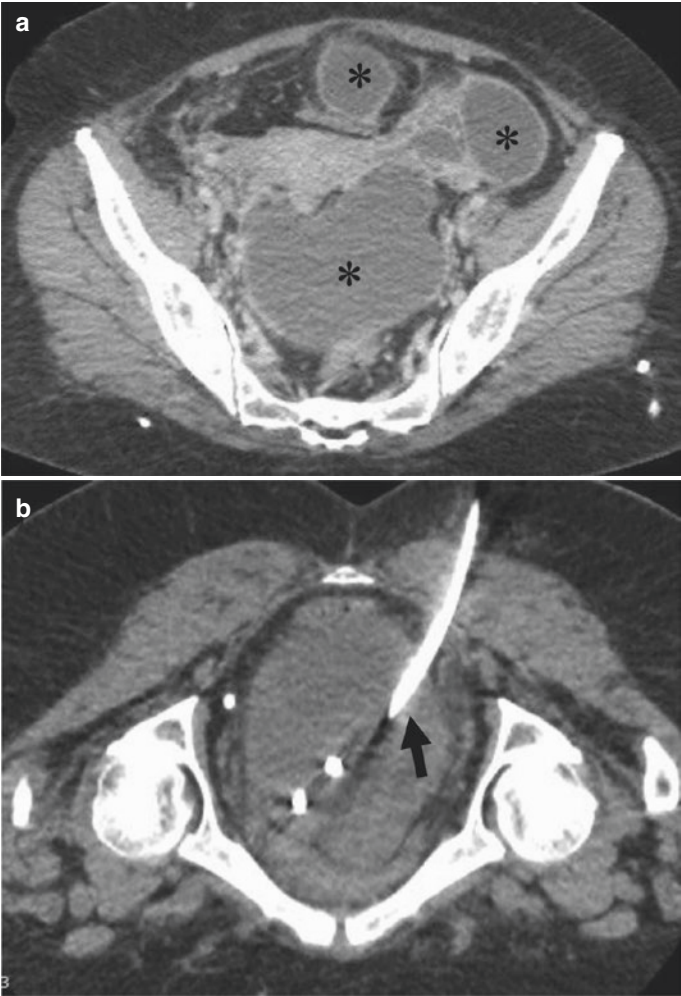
(a, b) Multiple pelvic abscesses (*) were drained percutaneously under CT guidance (arrow: pigtail catheter)
